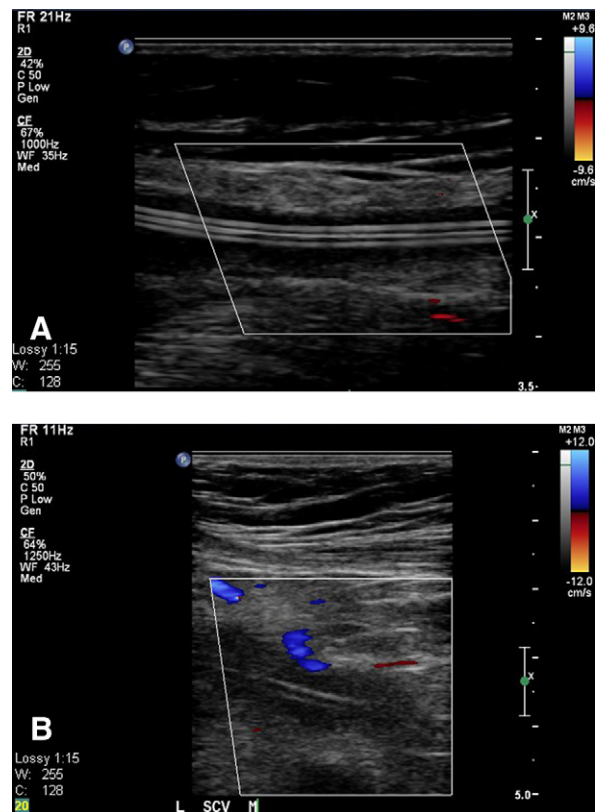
Ultrasound imaging shows catheter-induced thrombosis in the left arm of a 13-year-old girl. A, Acute thrombosis of the basilic vein is seen around the catheter. No flow is seen in the dilated lumen, with the catheter being very bright in the center and the thrombus being echolucent around it. B, Acute thrombosis of the subclavian vein is seen in the same patient. The catheter is seen in the lumen with absence of flow in the vein.
